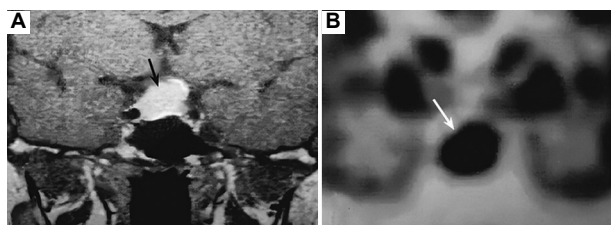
MRI and FDG PET/CT of a non-functioning pituitary adenoma (case 11). (A) MRI shows a 17 mm pituitary macroadenoma (black arrow). (B) ¹⁸F-FDG PET/CT demonstrates corresponding increased uptake in the pituitary fossa (white arrow; SUV_{max} 13.1). This figure is adapted from Seok *et al.*,²³ available under a Creative Commons Attribution (CC BY 4.0) license.
